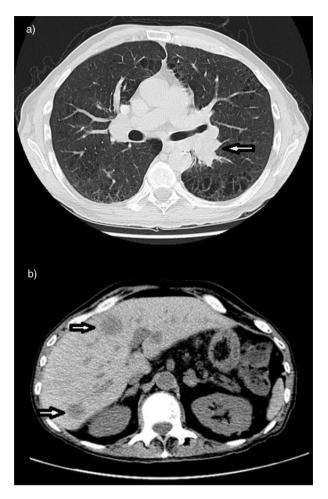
(a) Computed tomography of the chest with contrast showing speculated lung mass (arrow), (b) computed tomography of the abdomen with contrast showing multiple metastatic lesions in the liver.
